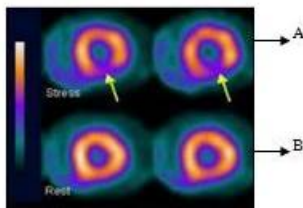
Cardiac SPECT perfusion images (A) indicates abnormal perfusion B) normal perfusion
